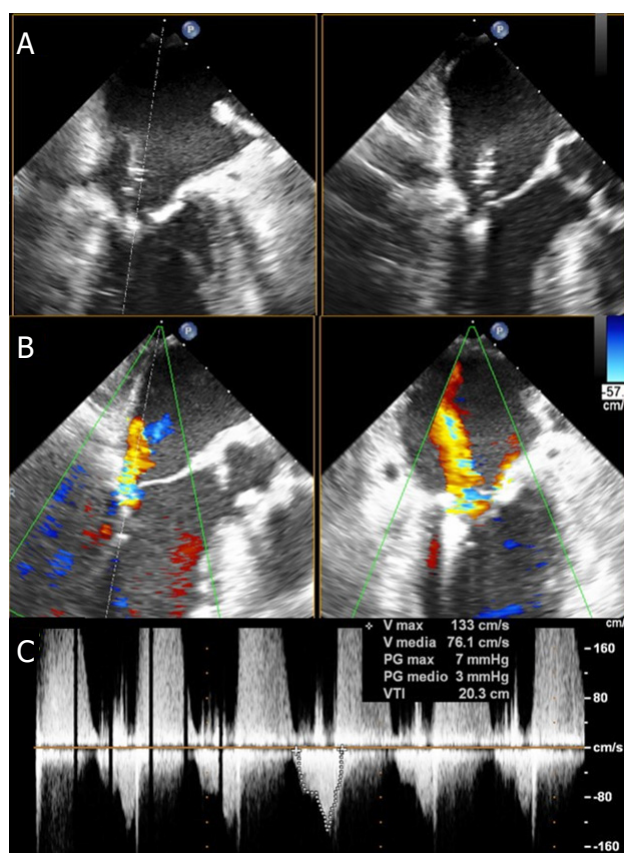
Intraprocedural trans-esophageal echocardiogram of XTR clip implantation: A3-P3 grasping (A), residual moderate mitral regurgitation located laterally to the clip (B) and transmitral gradients (C)
